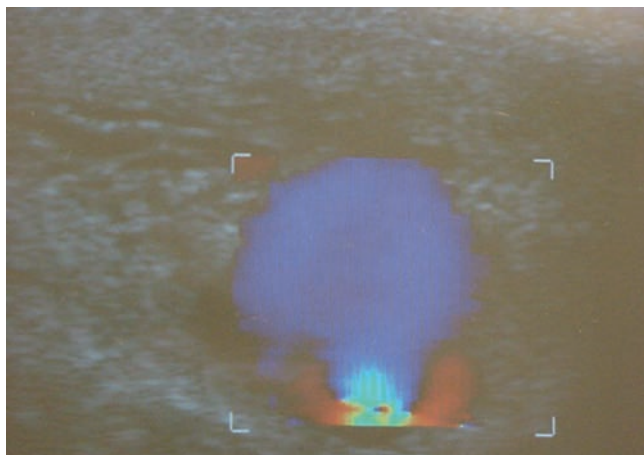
Color Doppler ultrasound typically shows the presence of arterio-sinusoidal malformation
